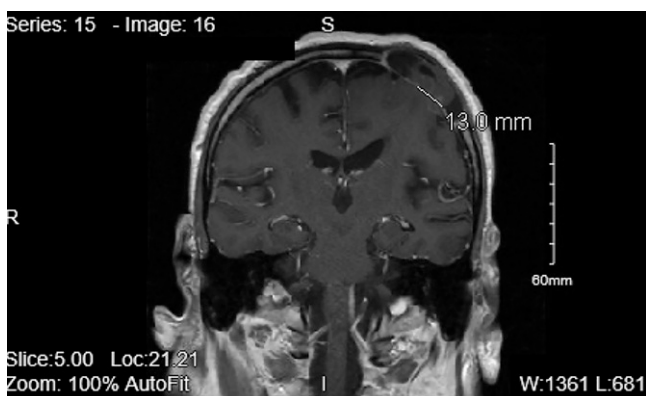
MRI of the brain with and without contrast showing cranial deficit and lesion, further depicting herniation.
